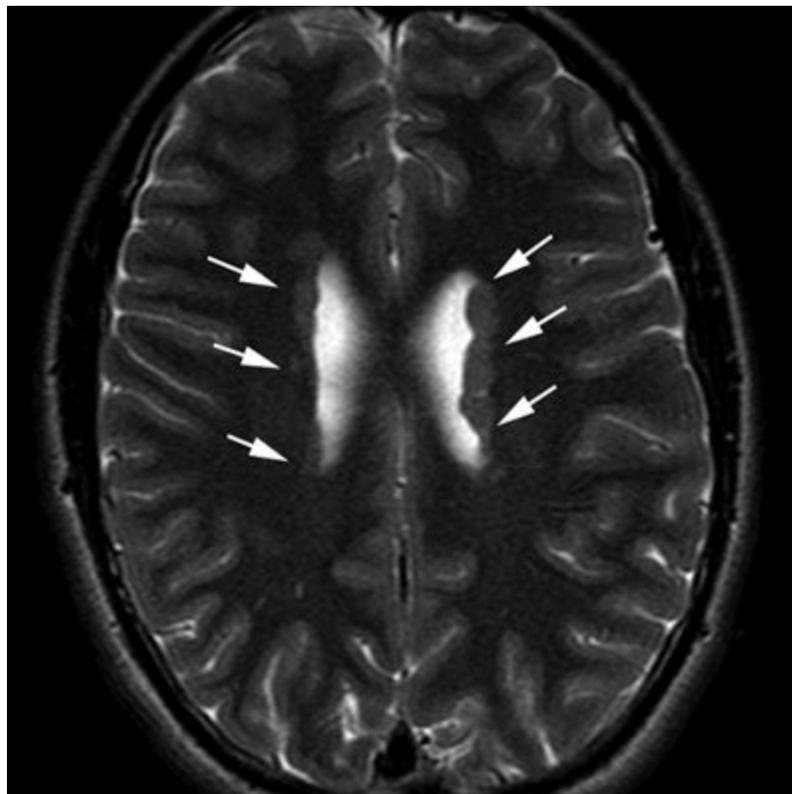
Subependymal (periventricular) heterotopia. Axial T2-weighted image from MRI without gadolinium in a 14-year-old female with history of ptosis and tremors shows gray matter nodularity lining the lateral ventricles bilaterally (arrows). Bilateral periventricular nodular heterotopia could be an X-linked dominant condition due to filamin A gene mutations.
